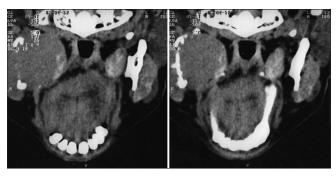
Computed tomography section presents a destructive soft tissue lesion in the posterior region of mandible and ramus
